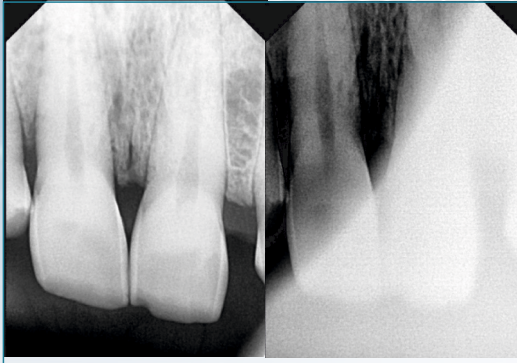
IOPA radiographs at presentation, showing vertical bone loss at 11 and 35
